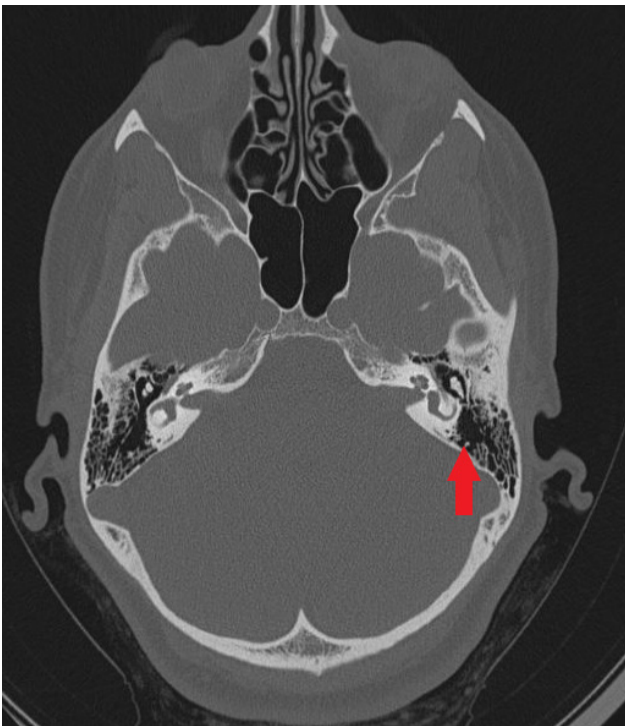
Axial CT image of ear. Arrow on the left indicating normal mastoid and tympanum
